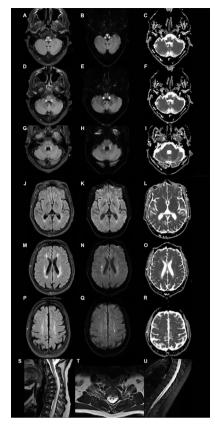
Axial section of the brain at the level of lower medulla shows signal abnormalities in the decussation of medial lemniscus and bilateral spinocerebellar tract on T2 fluid-attenuated inversion recovery (FLAIR) sequence (A). Diffusion restriction in image (B) with corresponding apparent diffusion coefficient in image (C). Axial section of the brain at the level of upper medulla shows signal abnormalities in the decussation of medial lemniscus, bilateral spinocerebellar tract and inferior cerebellar peduncle on T2 FLAIR sequence (D). Diffusion restriction in image (E) with corresponding apparent diffusion coefficient in image (F). Axial section of the brain at the level of lower pons shows signal abnormalities in the superior cerebellar peduncles, intraparenchymal trajectories of the trigeminal nerves and medial lemniscus on T2 FLAIR sequence (G). Hyperintensity in superior cerebellar peduncles and medial lemniscus in image (H) with no corresponding apparent diffusion coefficient in image (F). Axial section of the brain at the level of thalamus shows signal abnormalities in the juxtraventricular area around the body of lateral ventricle more significantly on left when compared with right (J). A punctate focus of diffusion restriction was noted near the body of the left lateral ventricle (K) with corresponding apparent diffusion coefficient in image (L). Axial section of the brain at the level of centrum semiovale shows signal abnormalities in the juxtraventricular, deep white matter area around the lateral ventricle (M). A punctate focus of diffusion restriction was noted near the lateral ventricle on the right side (N) with corresponding apparent diffusion coefficient in image (O). Axial section of the brain at the level of U fibres shows signal abnormalities bilaterally around the frontal horns of lateral ventricle, more significant on left when compared with right (Q). A punctate focus of diffusion restriction was noted near the frontal horns of lateral ventricle on the left side (R) with corresponding apparent diffusion coefficient in image (O). Sagittal section of cervical spine MRI shows T2 hyperintense signal over its entire length but more significant at levels C2 to C4 (S). Axial section of cervical spine shows signal abnormalities in the dorsal column and lateral corticospinal tract (T). Image (U), a sagittal section of MRI of thoracic spine, shows T2 hyperintense signal over its entire length.
